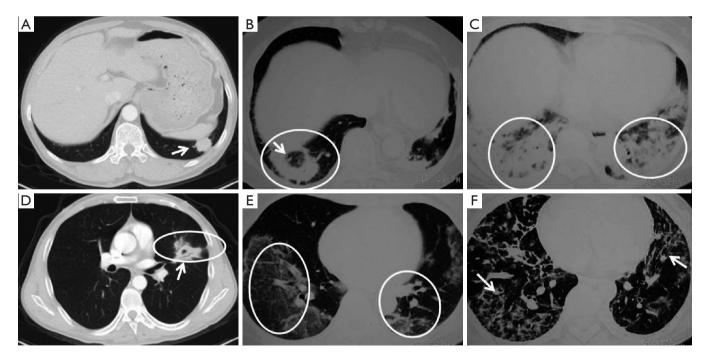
Lesion types on chest CT of patients with COP. Patients with COP showed diverse types of lesions on Chest CT, including nodules (A, arrow), reversed halo sign (B, arrow), diffuse consolidation (C), lung consolidation with air bronchogram (D, arrow), patchy ground glass (E), fibrous stripes (F, arrow). COP, cryptogenic organizing pneumonia.
